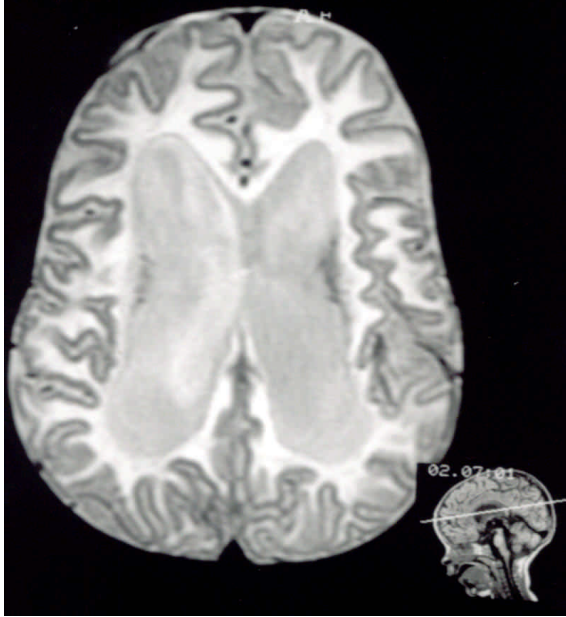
A MRI of the brain of a two-year-old girl with Canavan disease showing advanced demyelination with diffuse white matter changes. Demyelination also involves the entire subcortical white matter.
